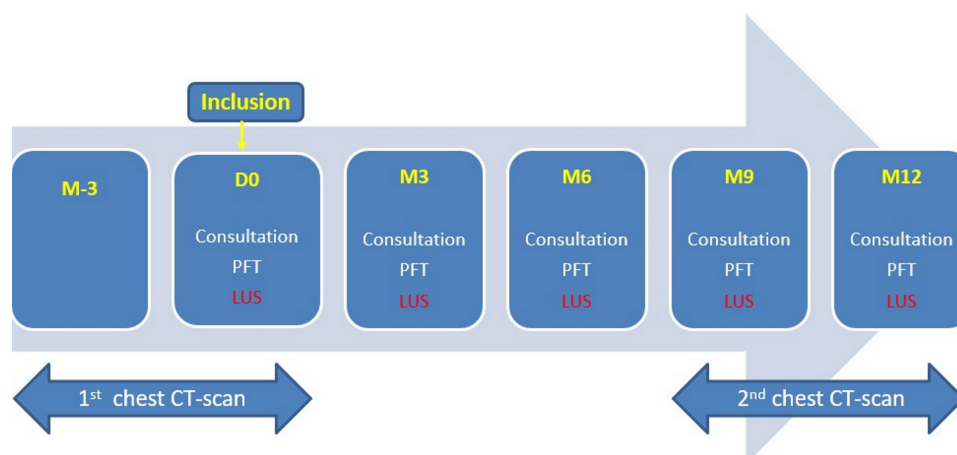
TOUPIE study design. TOUPIE, ThOracic Ultrasound in Idiopathic Pulmonary Fibrosis Evolution.
